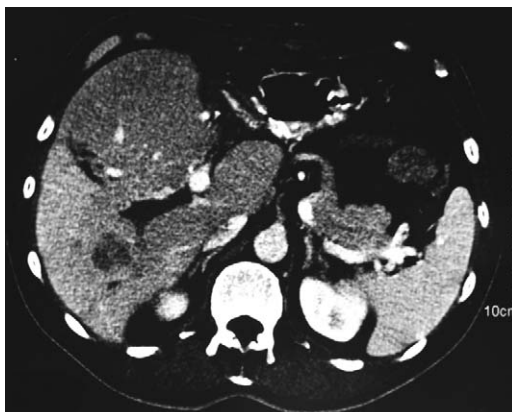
Abdominal CT scan after first-stage hepatectomy: left lobectomy associated with a right PVE.
